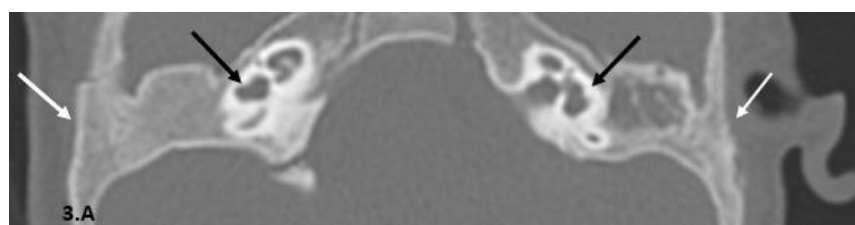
A: Axial CT view, bone window revealed bilateral external auditory canal bony atresia (white arrows). bilateral cystic dilatation of the vestibules (black arrows).
